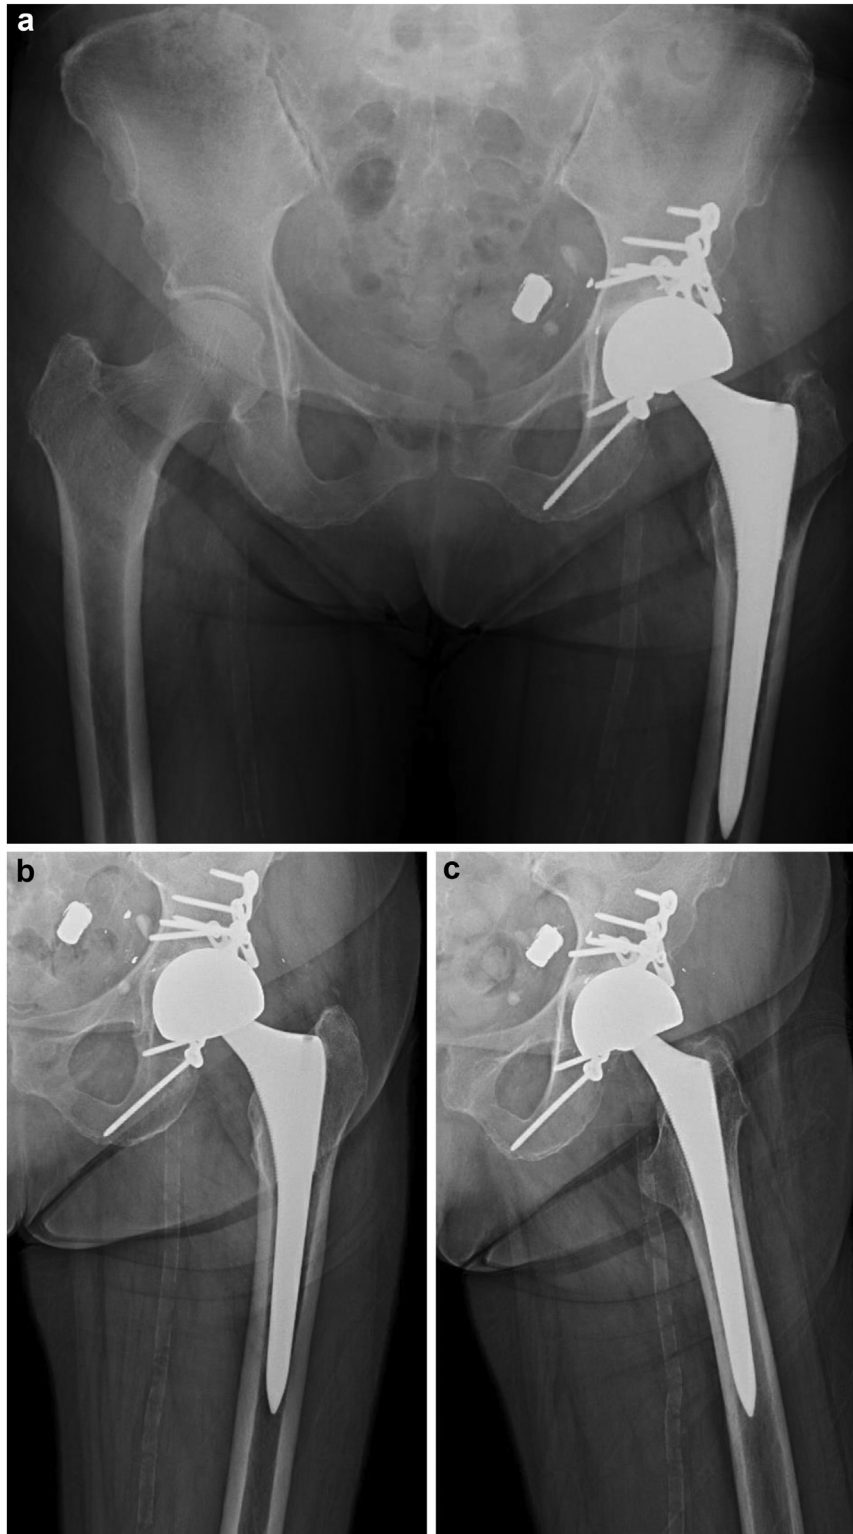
During the patient's 18-month postoperative visit, radiographs were obtained for routine monitoring and included (a) AP pelvis, (b) AP left hip, and (c) lateral left hip.
